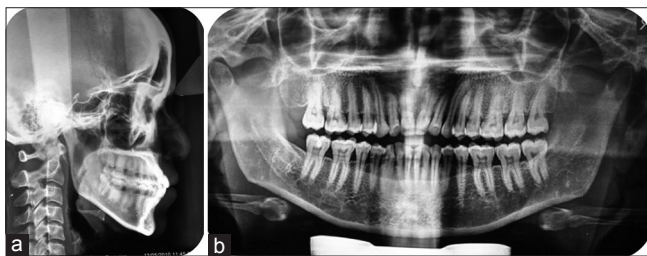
(a and b) Pretreatment radiographs
